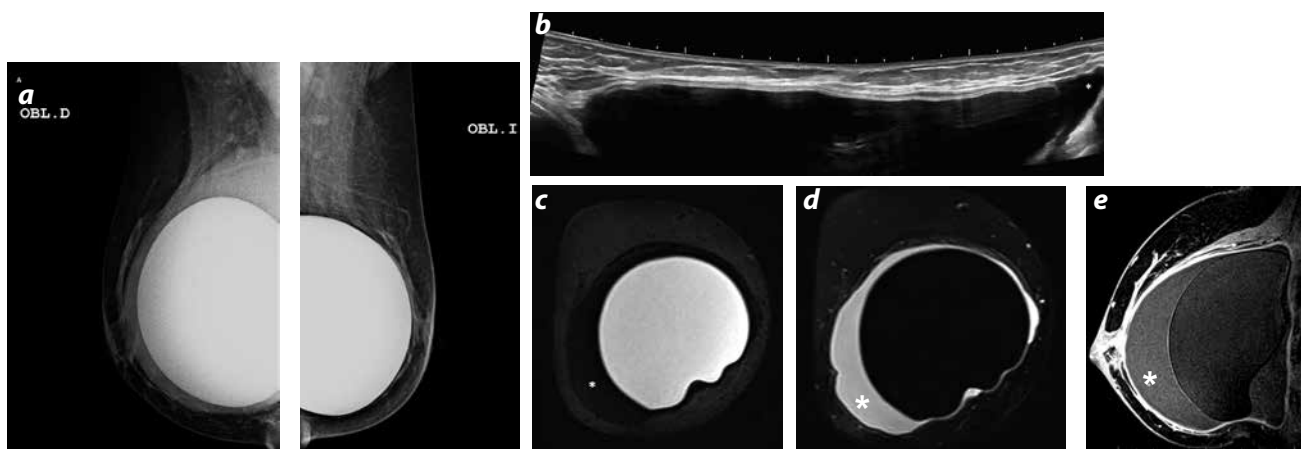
Late seroma. Silicone implant antecedent 7 years ago. a) Retropectoral implants with increase of peri-prosthetic density in the right side. b) Extended field ultrasound: intact breast implant with peri-prosthetic liquid (\*). c and d) MR right breast: coronal images, STIR sequences, water suppression and silicone suppression; intact implant, surrounded of intracapsular liquid (\*). e) MR right breast: sagittal image T1-3D FS with contrast medium: right peri-prosthetic liquid with discretely high signal (\*). Aspirated liquid report: reactive cellularity without atypical cytology. Negative cultures for bacteria, fungi and microbacteria.
